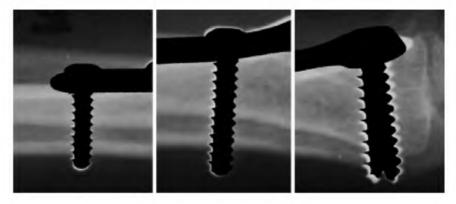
Three sections of the comparison are viewed after digital adjustments are made to correct for slight dimension differences between the two x-rays.
